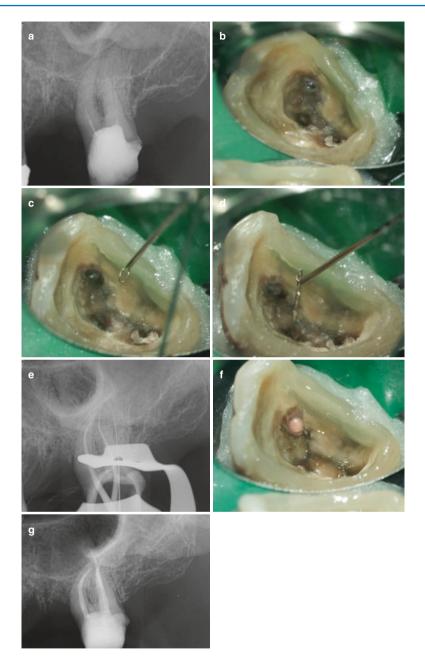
(a) Initial radiograph of a maxillary second left molar with a fragment in the coronal third of the mesiobuccal canal. (b) Exposure of the coronal segment of the fragment. (c) Creation of a wire loop to attach the fragment. (d) Removal of the fragment with the wire loop technique using the Frag Remover (Frag Remover HanCha-Dental, Zwenkau, Germany). (e) Working length determination radiograph of the mesiobuccal canal. (f) Immediate post-obturation clinical image of the pulp cavity. (g) Final radiograph (Courtesy of Dr. M. Leineweber)
